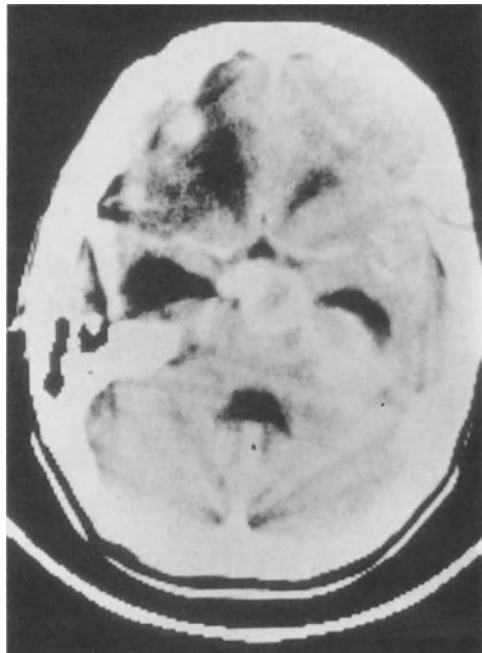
CT scan showing giant basilar aneurysm
